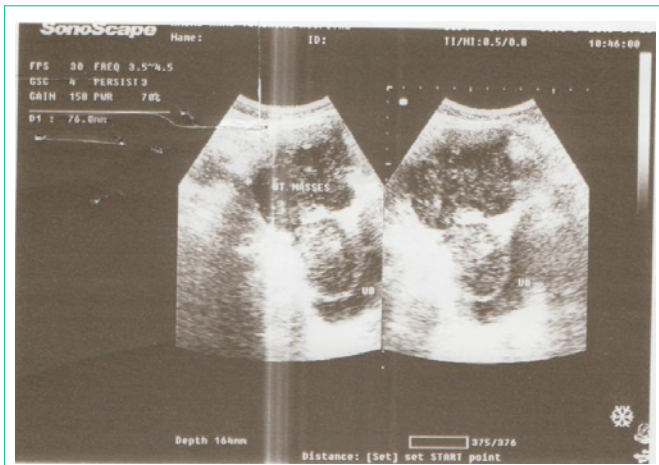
Pelvic ultrasound scan showing pelvic multi nodular mass.
